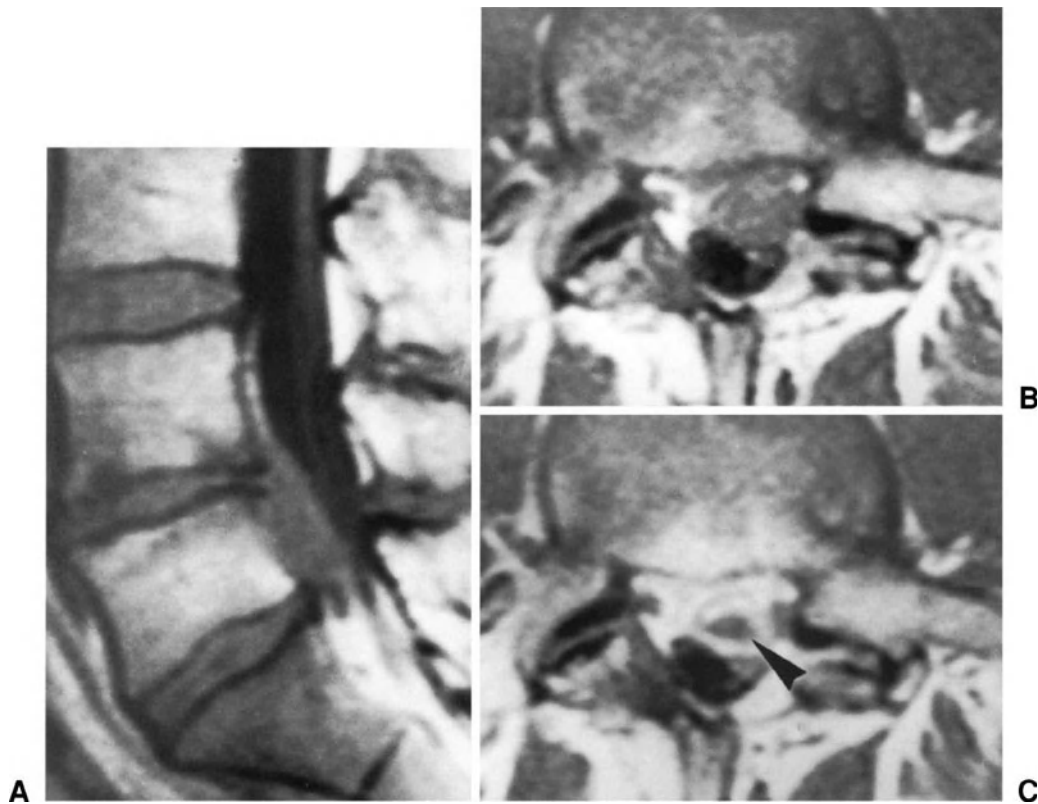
Recurrent L4-L5 disc herniation on the left. (A) and (B) Spin-echo T1-weighted MR sagittal image and spin-echo T1-weighted axial image showing pathologic tissue, isointense to the disc, anteriorly to the thecal sac. (C) Spin-echo T1-weighted axial image obtained after injection of gadolinium: the pathologic tissue shows signal enhancement in the peripheral, but not the central, portion (arrowhead). These findings indicate the presence of a recurrent disc herniation surrounded by scar tissue.
